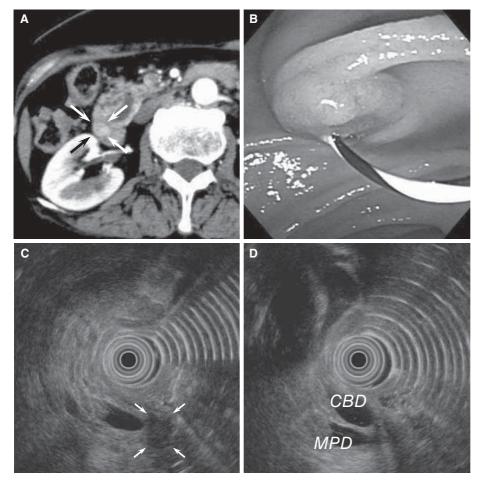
A Computed tomography image showing a heterogeneously enhanced mass of $12 \times 10 \,\mathrm{mm}$ in the ampulla of Vater (*arrows*). B Endoscopic examination showed a polypoid, exophytic mass of the ampulla of Vater. C, D Transduodenal endoscopic ultrasonography showed a heterogeneous hypoechoic mass of about 10 mm in the ampulla of Vater without infiltration into the pancreas or muscularis propria of the duodenum (*arrows*). *CBD*, common bile duct; *MPD*, main pancreatic duct
